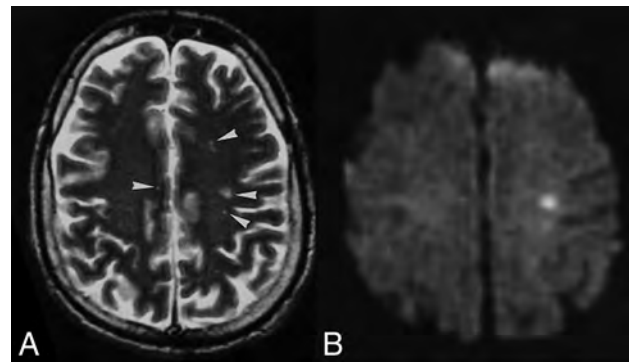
Patient with Nipah virus infection: initial infection. A, Multiple punctate white matter lesions (arrowheads) are visible on T2-weighted FSE MR image. B, The largest lesion is more prominent on corresponding DWI. Images reprinted from Lim et al.³¹
